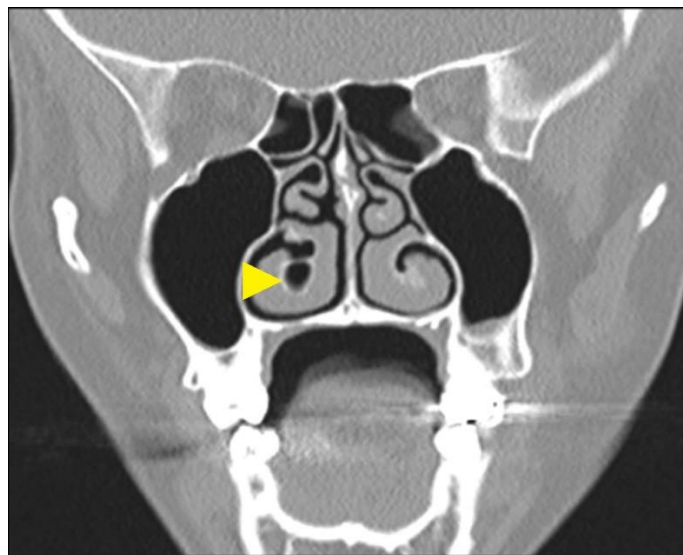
Coronal CT section showing right sided pneumatized inferior turbinate (Yellow arrow head)
